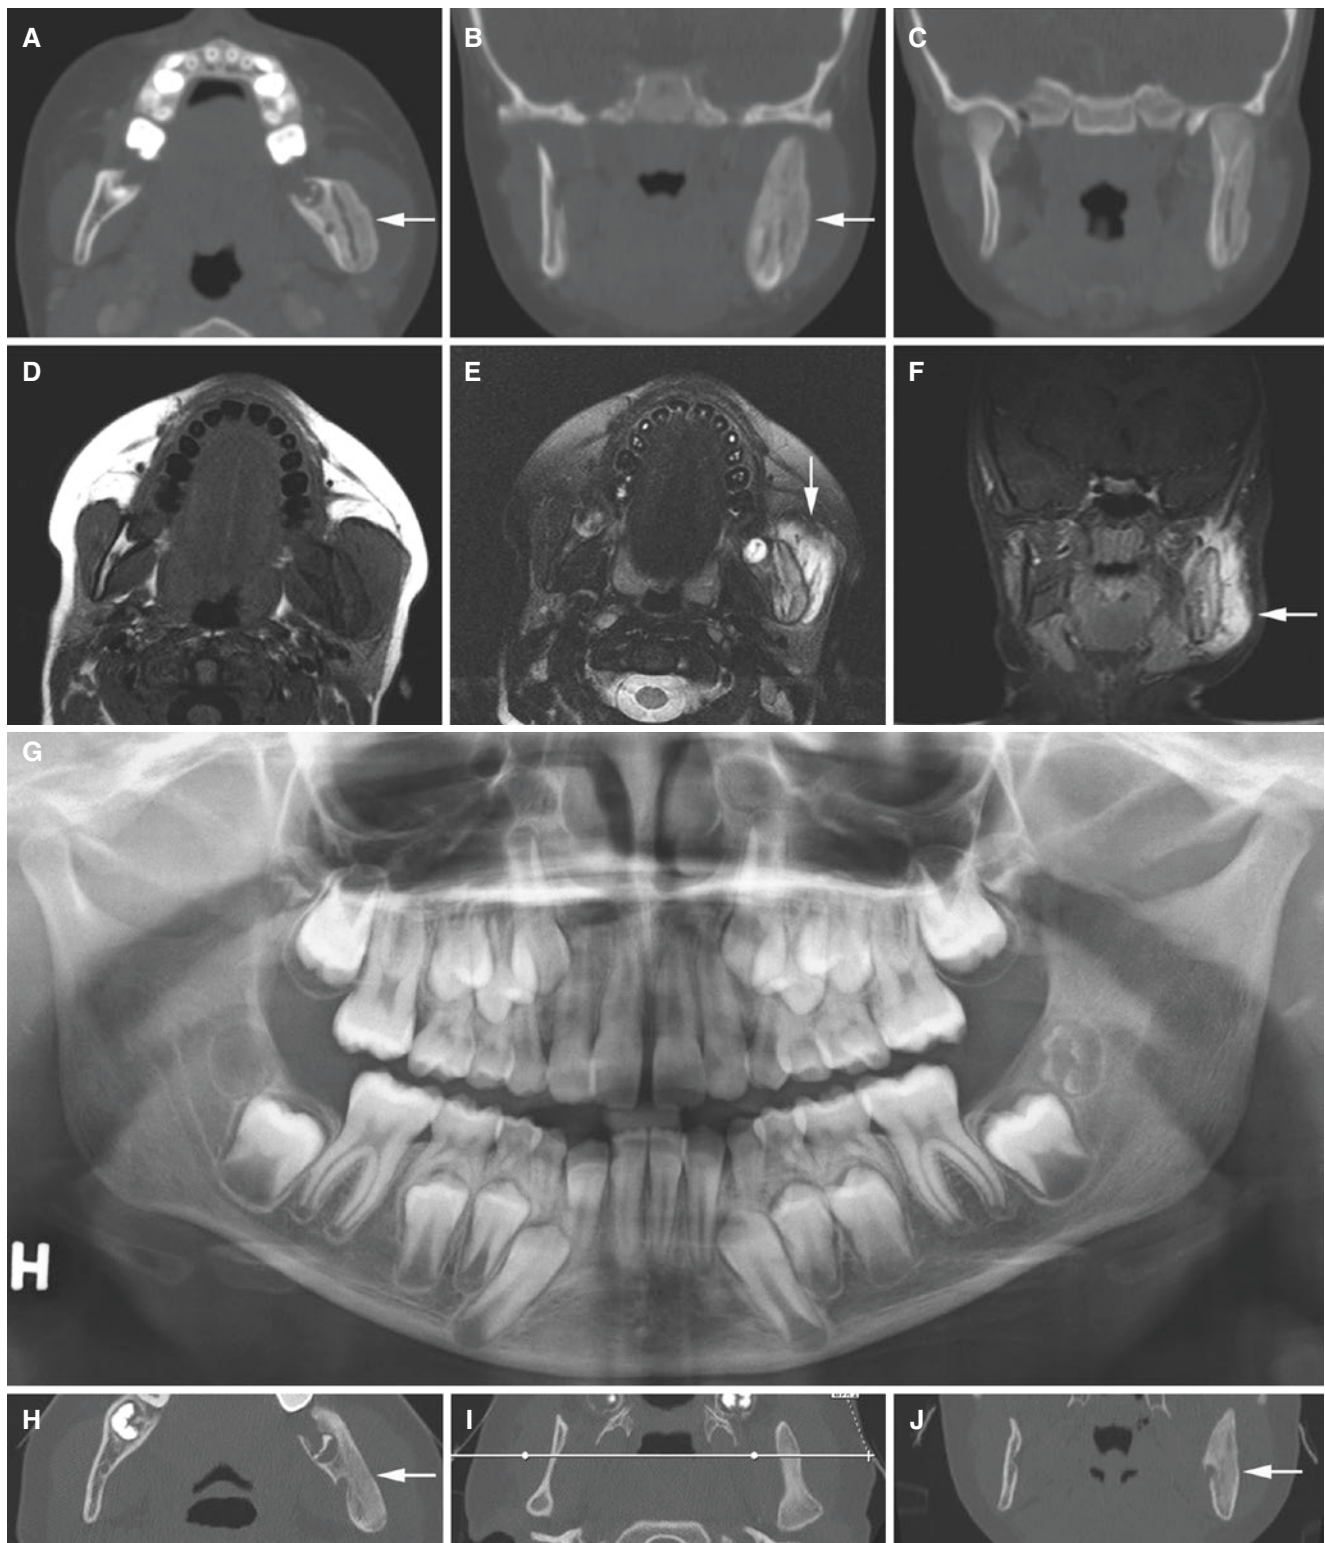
Osteomyelitis with periostitis, mandible; 9-year-old female with left-sided facial swelling. (A) Axial and (B, C) coronal CT images show large buccal and small lingual periosteal bone apposition (*arrow*). (D) Axial T1-weighted, (E) axial T2-weighted, and (F) coronal T1-weighted fat sat post-Gd MRI show high signal intensity on T2
